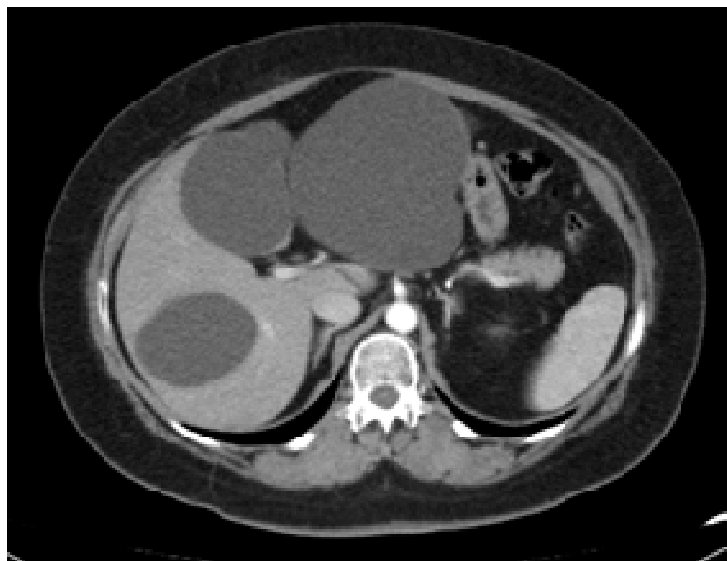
Abdominal CT of a patient with multiple simple cysts, involved both hepatic lobes; arterial phase
